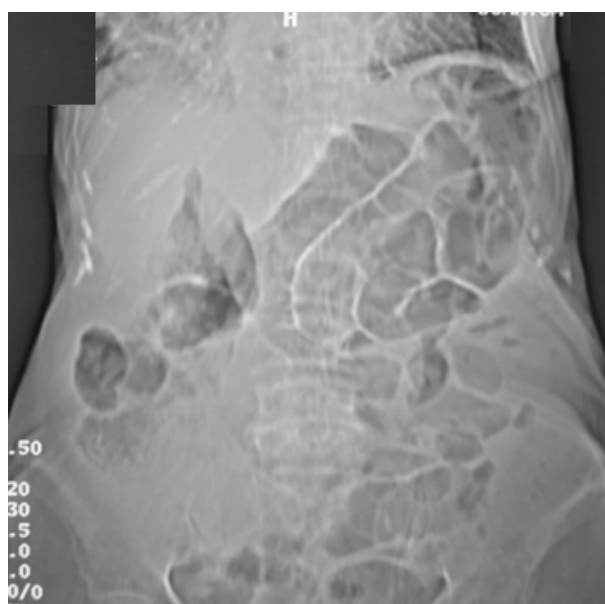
Centered abdominal X-ray: dilated right and left colon with multiple air-fluid levels specific of both colic and small bowel obstruction.
